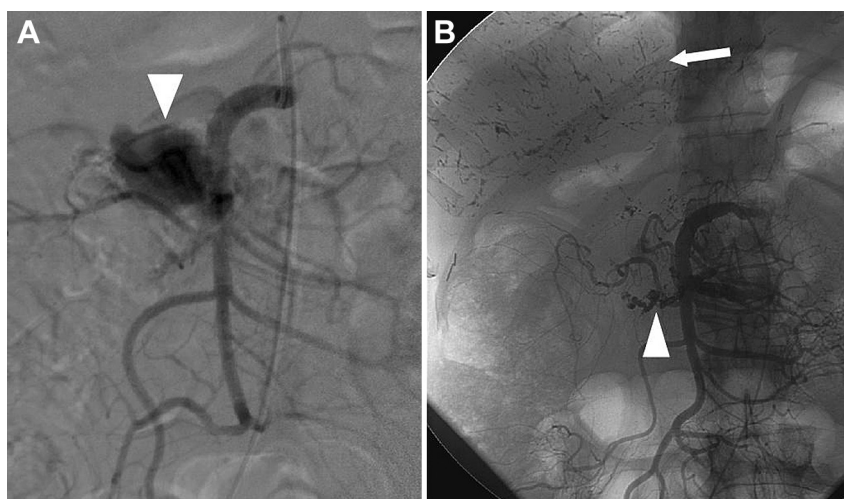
A 64-year-old male with chronic pancreatitis presented with melaena. (A) Selective digital subtraction angiography (DSA) shows the pseudoaneurysm (arrowhead) arising from the inferior pancreaticoduodenal artery. An initial attempt to embolize with *N*-butyl cyanoacrylate failed because of arterio-portal shunting. Later, embolization was performed intra-operatively by direct injection of *N*-butyl cyanoacrylate into the pseudoaneurysm under ultrasound guidance. (B) DSA following intra-operative embolization shows no reperfusion of pseudoaneurysm (arrowhead). Note glue cast in small intrahepatic portal radicals (arrow).
